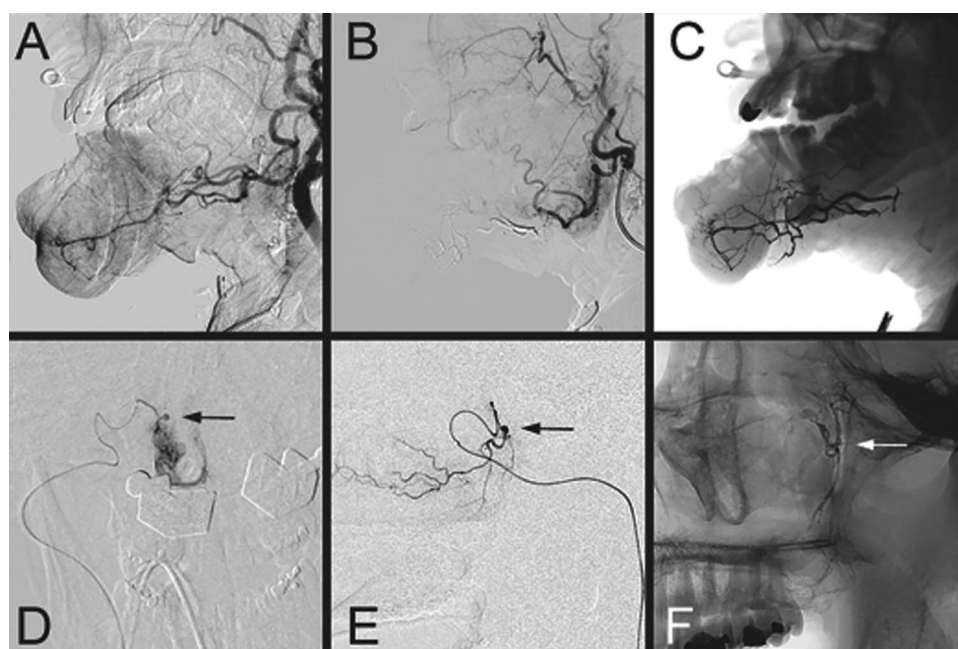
(A–C) A patient with squamous cell carcinoma of the mandible that was bleeding profusely, resulting in symptomatic anemia. (A) Lateral view pre-embolization angiogram showing tumor vascularity. (B) Lateral view postembolization angiogram showing tumor devascularization. (C) Lateral postembolization X-ray picture showing Onyx cast in the facial artery feeders bilaterally. (D–F) A patient with intractable epistaxis 3 days after endoscopic sinus surgery. (D) Anteroposterior microangiogram of the right sphenopalatine artery and traumatic pseudoaneurysm (arrow). (E) Lateral view of the right sphenopalatine artery microangiogram demonstrating the pseudoaneurysm (arrow). (F) Lateral postembolization X-ray picture showing the N-butyl-2 cyanoacrylate cast in the sphenopalatine artery (arrow).
